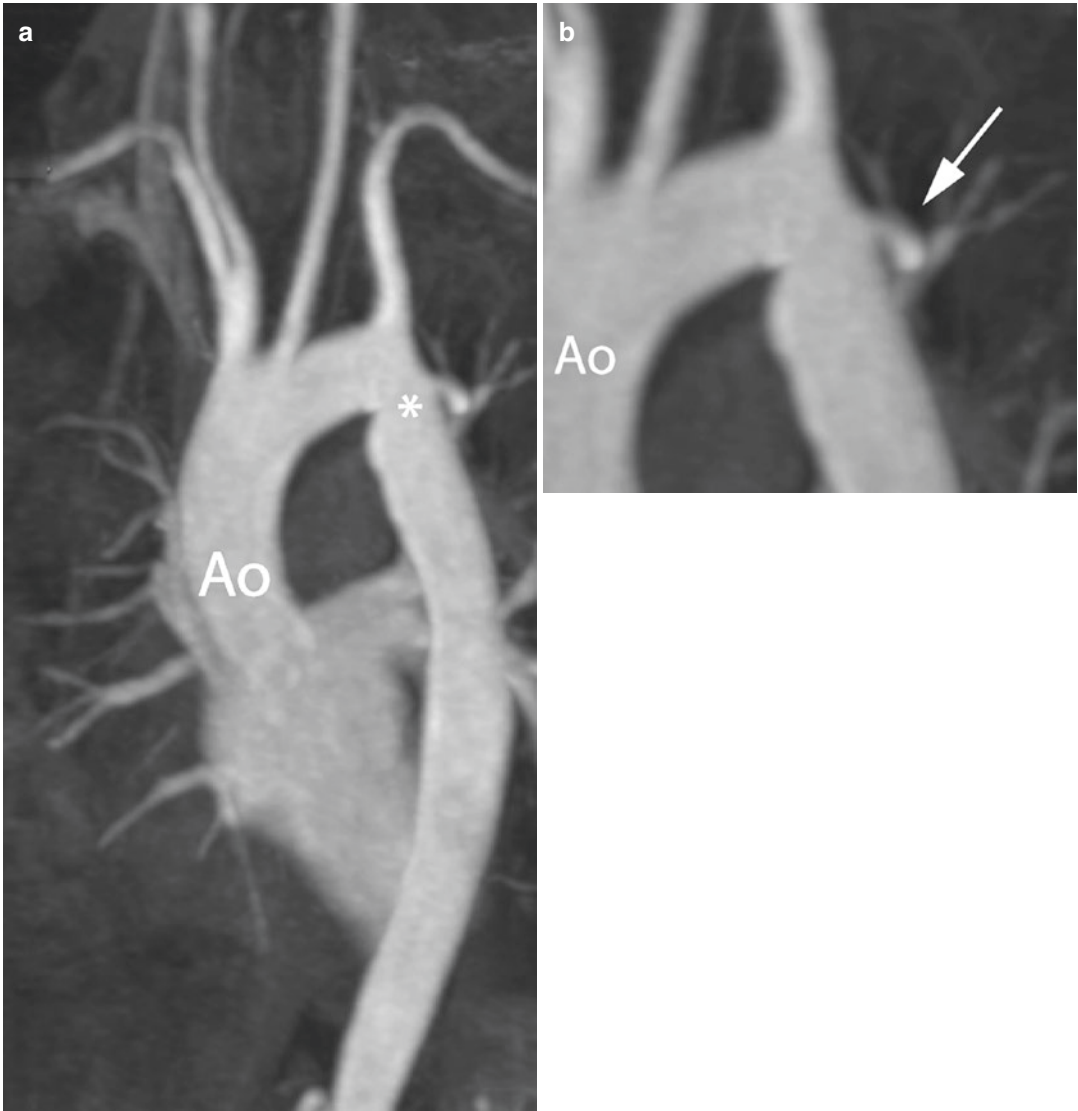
Aneurysm after coarctation repair. CT angiography of a 35-year-old male after end-to-end anastomosis for coarctation of the aorta (a). A small aneurysm (*arrow*
